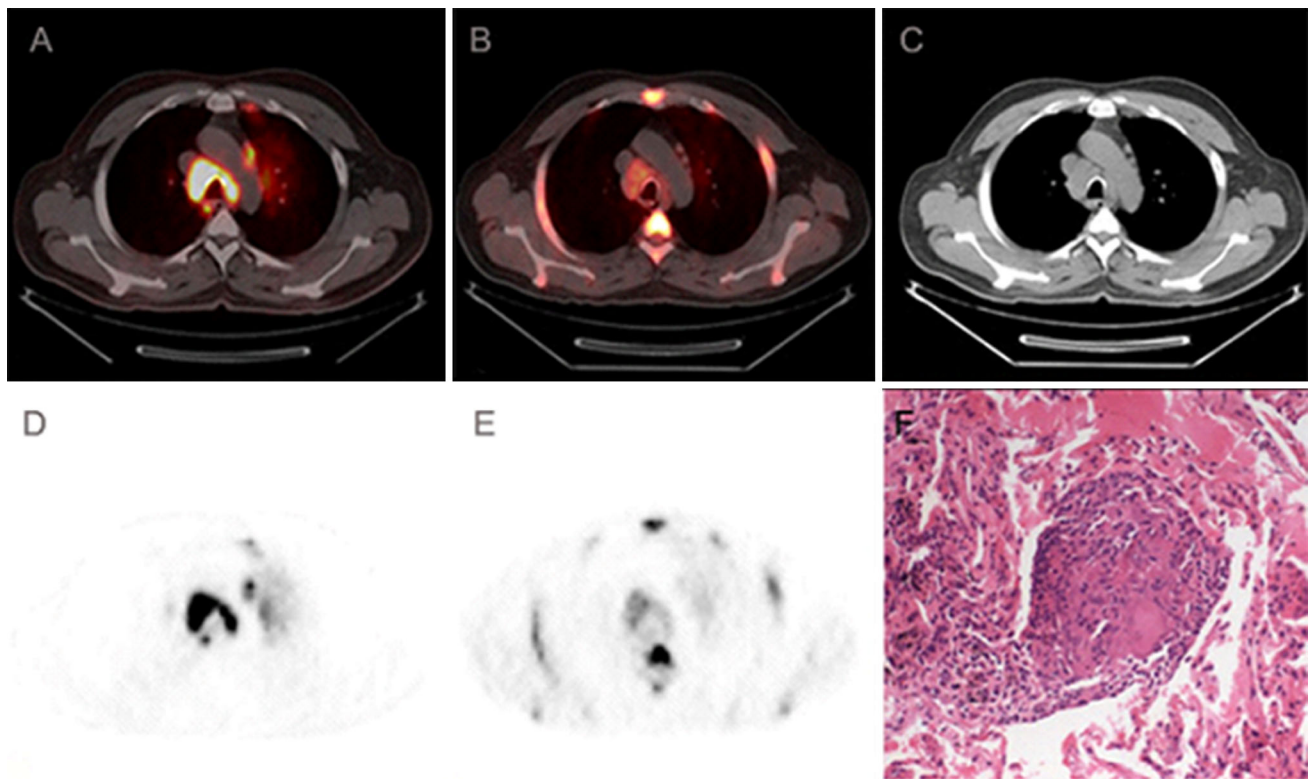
Transaxial fused ^{18}F -FDG PET/CT (a) and ^{18}F -FLT PET/CT (b), CT only (c), FDG PET only (d) and FLT PET only (e) showing increased tracer uptake in paratracheal lymph nodes in a sarcoidosis
